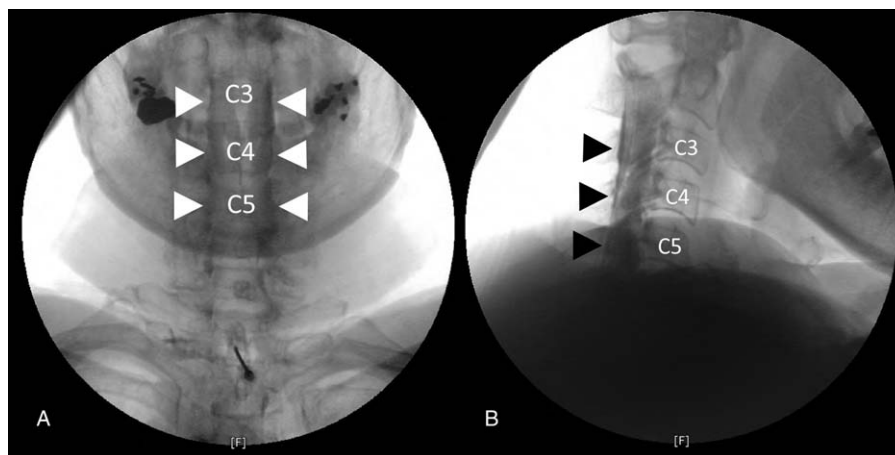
Cervical anteroposterior (AP) and lateral views after injection of 1.5 mL of water-soluble contrast media through the catheter, (A) cervical AP radiograph shows bilateral spread of the contrast media (white arrow). (B) Cervical lateral radiograph shows the spread of contrast media in the upper cervical epidural space including C3–C5 (black arrow).
